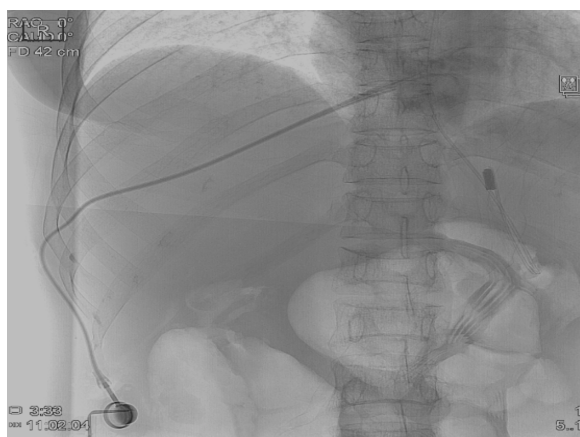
Frontal radiograph showing the transhepatic subcutaneous port placement of the patient.
